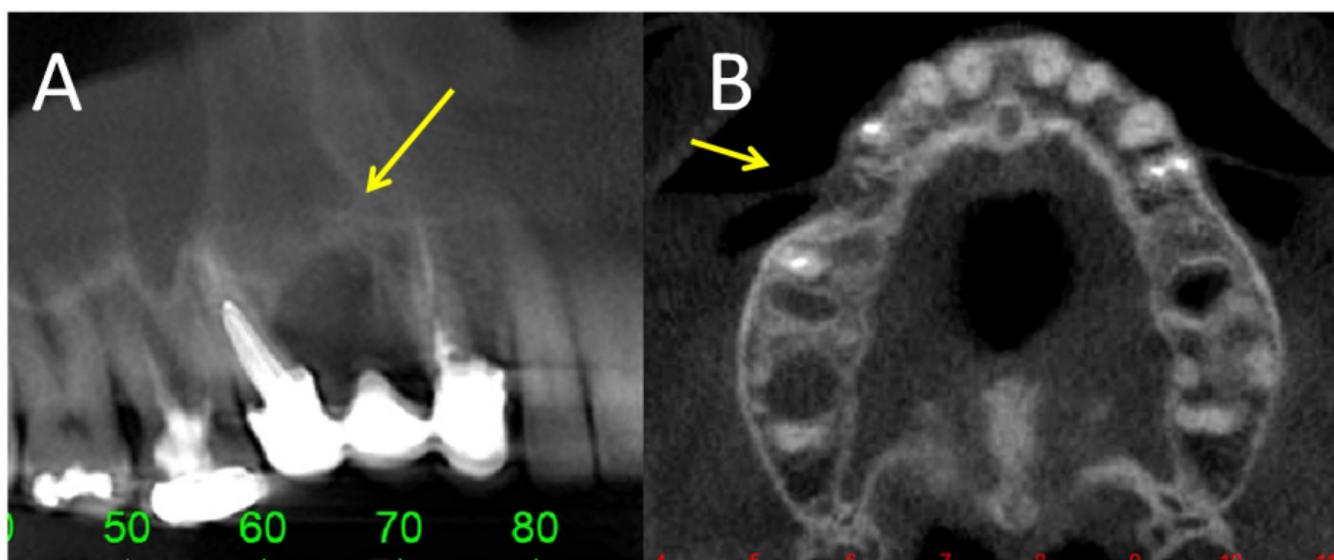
Cone beam computed tomography performed prior to the excisional biopsy reported by the patient in her history. Hyperdense image, dome of regular contour on the floor of the right maxillary sinus (images A and B, yellow arrow), suggestive of antral pseudocyst.
